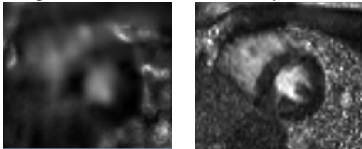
Examples of low (left) and high resolution T1-weighted images; midventricular short-axis image
